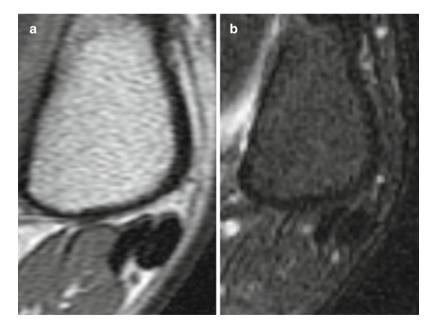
(a, b) MRI of the left ankle shows no remarkable abnormality
